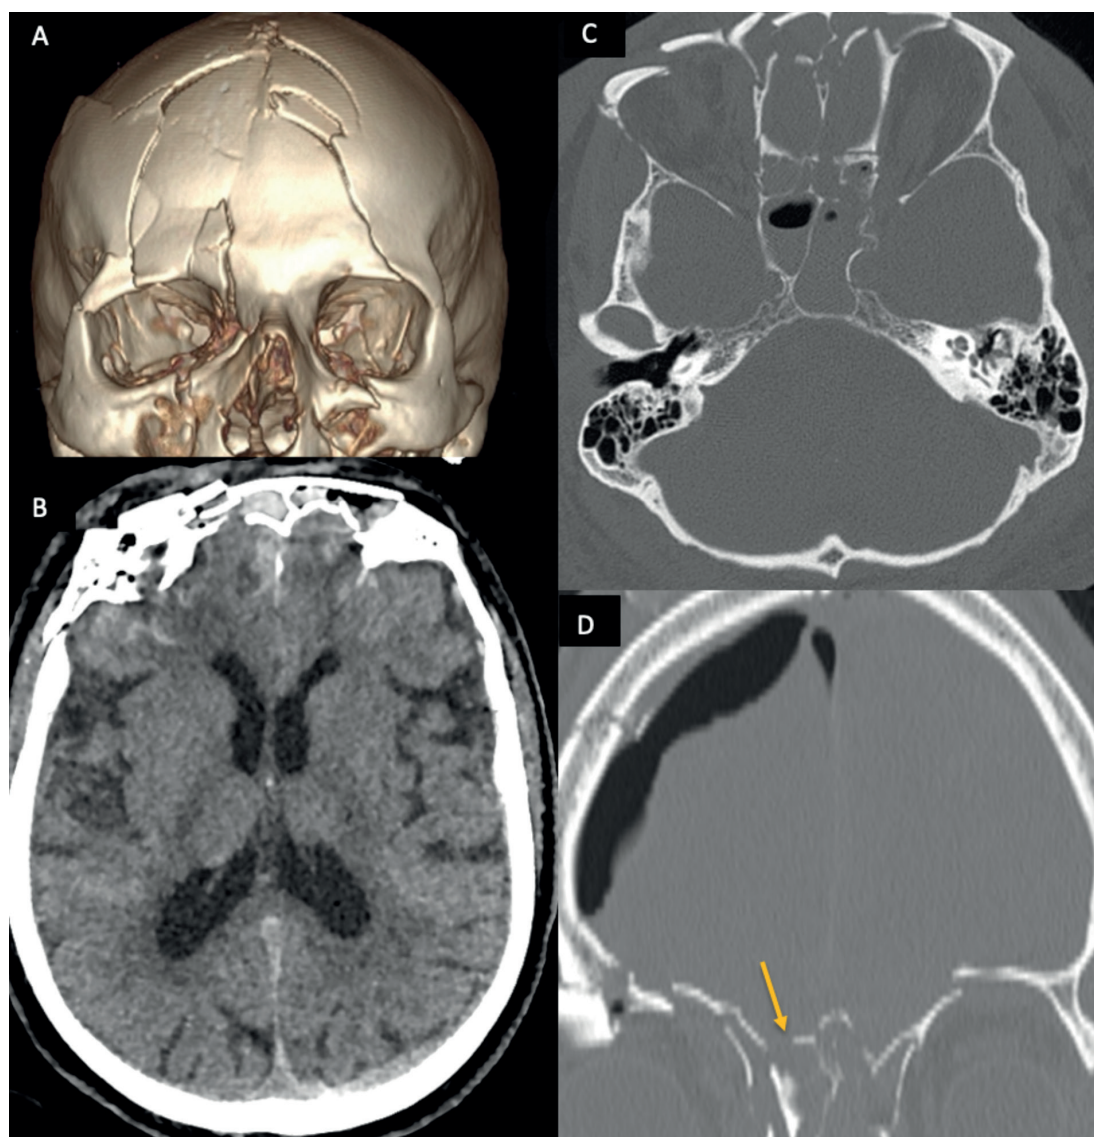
Cerebral CT-scan at patient's admission. A, 3D reconstruction of craniofacial fractures. B, Axial view of the frontal sinus fractures with posttraumatic subarachnoid haemorrhage and minimal acute parieto-occipital subdural hematoma. C, Axial view of the skull base fractures within the anterior ethmoidal and sphenoidal sinus. D, Coronal view showing fractures involving the frontal bone, roof of the orbit and cribriform plate (*arrow*). Intracranial pneumocephalus is also noted.
